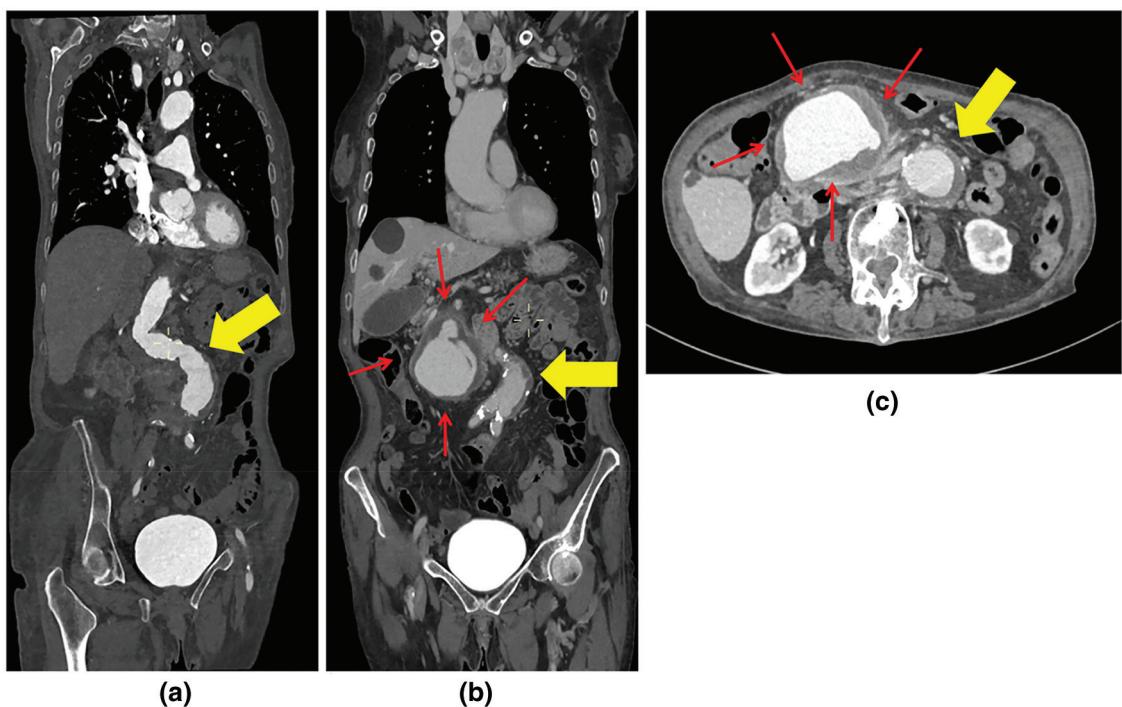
Preliminary CT scan. CT imaging showing coronal (a,b) and axial (c) reconstructions of a scoliotic and stretched abdominal aortic aneurysm (yellow arrows) with part of its sac filled with thrombus and the presence of a giant pseudoaneurysm of the middle colic artery (red arrows).
